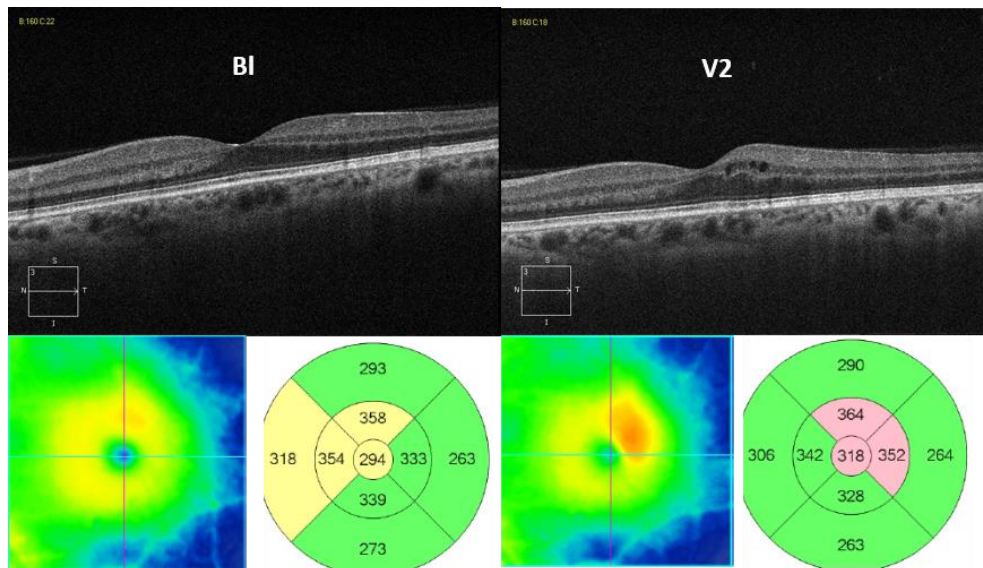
Choroidal morphologic changes in a macular edema progression. On baseline image (left), of a mild NPDR eye, we can observe the loss of the inverted dome shape of SCI, irregular vessels layers with focal zones of loss of great vessels, atrophy or hypertrophy of ChS, but with no evident retinal changes. Six months later there was a CME with an increase in CT from 219 to 248 μ with a change in choroidal vessels with more larger vessels near the posterior border of Bruch's membrane.
